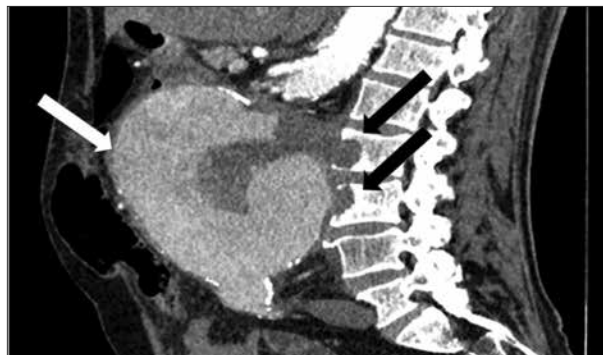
Sagittal computed tomography reconstruction showing the aortic aneurysm (white arrow) and discovered erosions of the anterior and lateral parts of the vertebral bodies L2 and L3 (black arrows)
